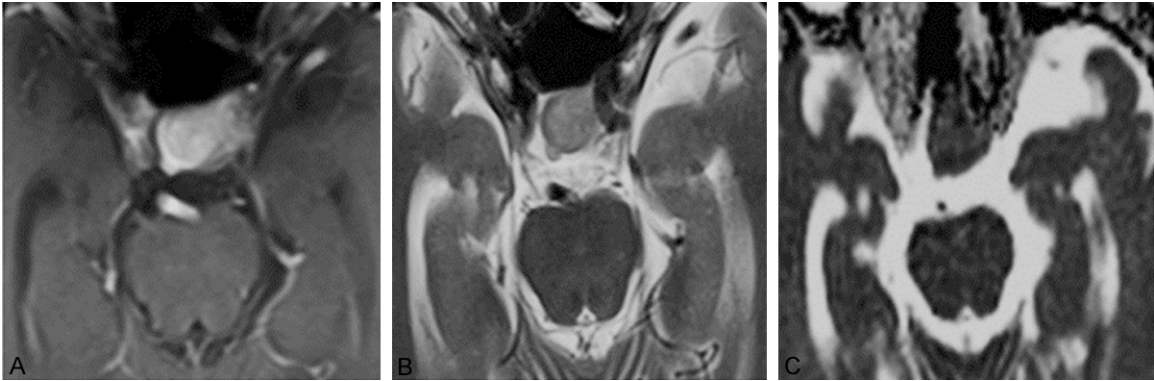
MRI images of 1 case of medium texture PA. A. Enhanced axial MRI image. B. Axial T₂WI image. $T_{2PA} = 0.657 \times 10^{-3} \text{ mm}^2/\text{sec}$, $T_{2ME} = 0.350 \times 10^{-3} \text{ mm}^2/\text{sec}$, $R_{T_2} = 1.88$. C. Axial ADC image. $ADC_{PA} = 0.721 \times 10^{-3} \text{ mm}^2/\text{sec}$, $ADC_{ME} = 0.784 \times 10^{-3} \text{ mm}^2/\text{sec}$, $R_{ADC} = 0.92$.
